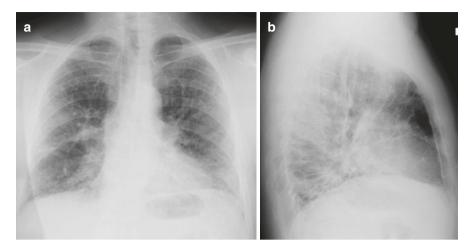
(a) Posteroanterior chest X-ray: reticulations bilaterally, especially dorsally, basally. (b) Lateral chest X-ray: reticulations dorsally
